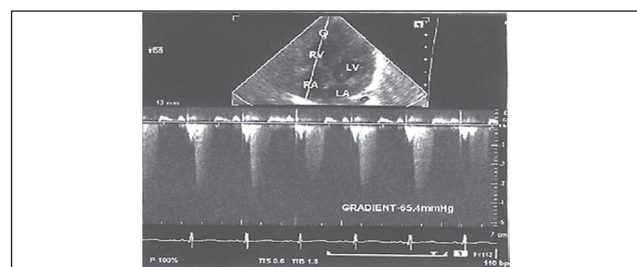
Continuous wave Doppler showing gradient across the turbulent flow.
